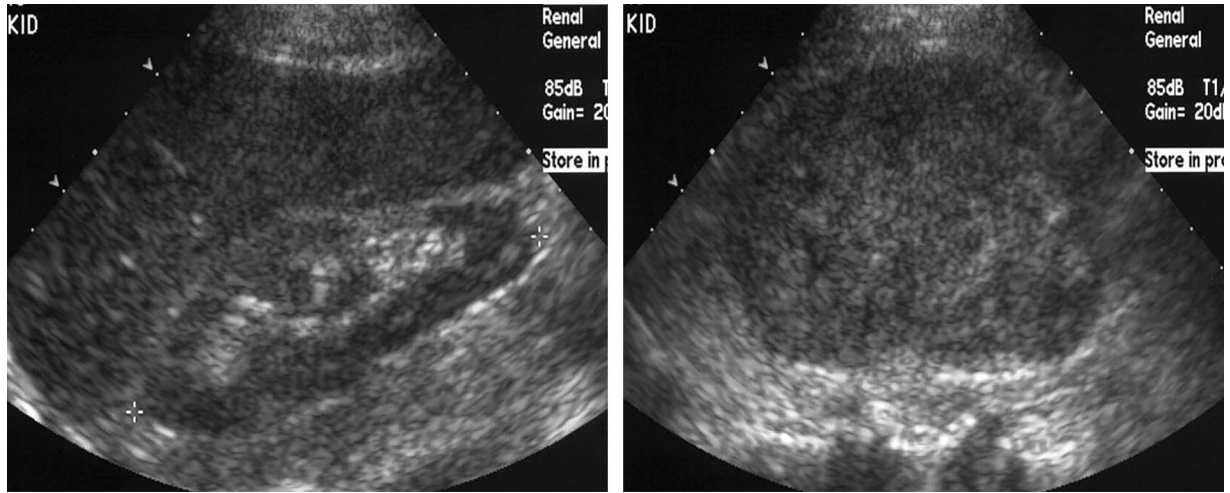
Faceless kidney sign. (a, b) Kidney with (a) and without (b) a face. (c) Unenhanced CT image through the kidneys shows absence of the typical sinus signature in the left kidney. (d) Contrast-enhanced image, obtained at the same level as seen in c, shows normal parenchymal enhancement. (e) Delayed image obtained at the lower aspect of the left kidney shows the presence of two ureters (arrowheads). (f) Excretory urogram demonstrates duplication of the left collecting system, with the two separate collecting system elements and two ureters exiting the kidney. It is easy to see how the images in c and d were generated from a position between the collecting system elements.
